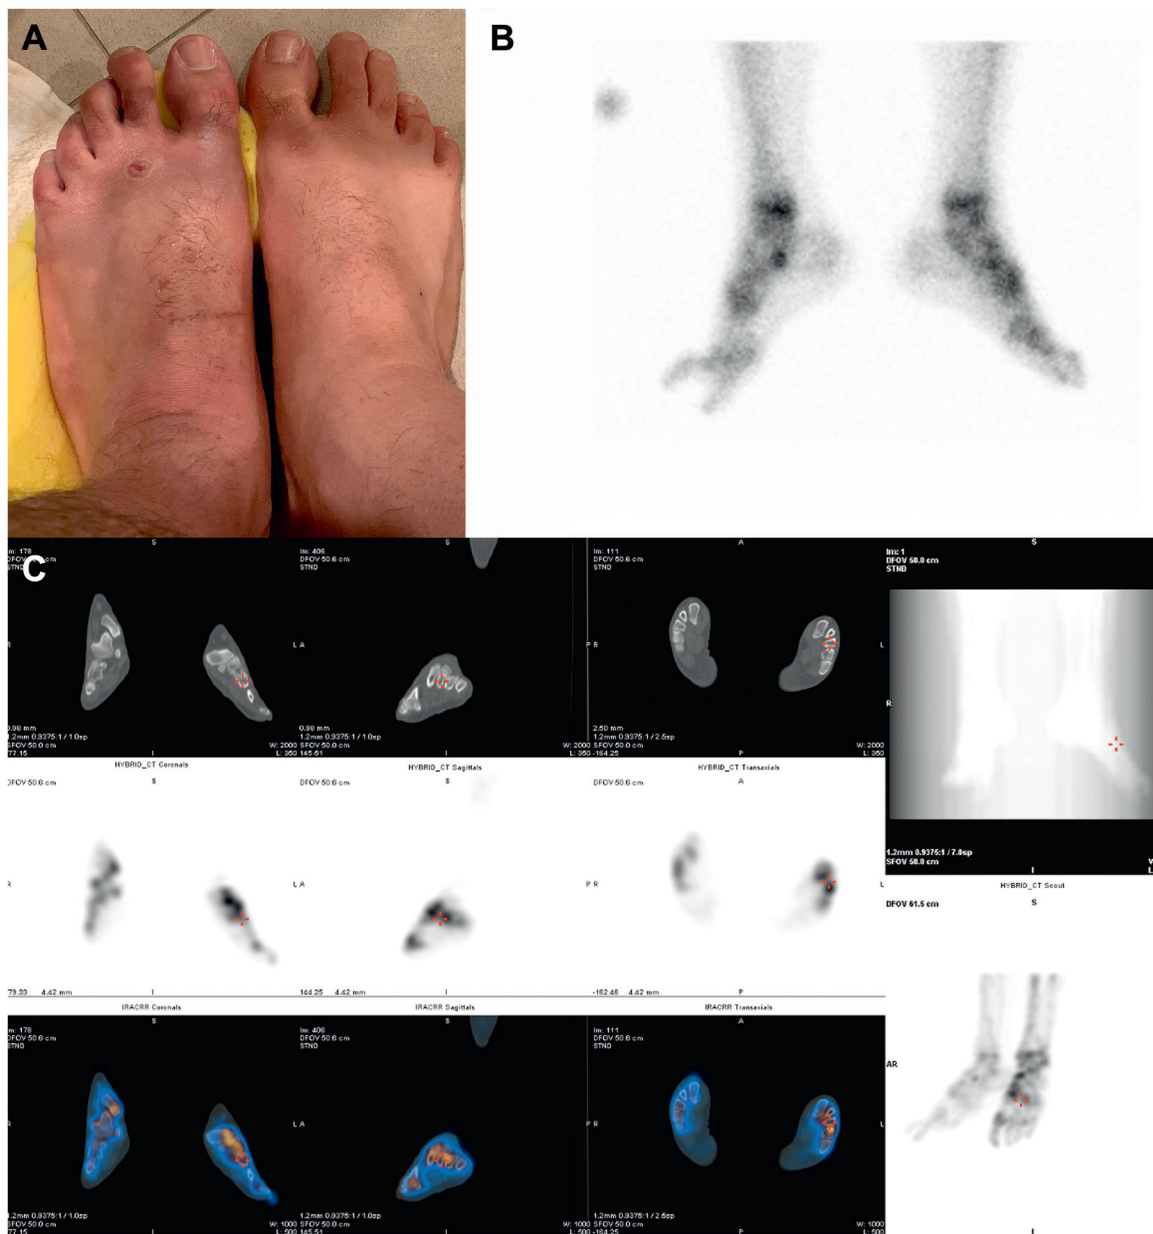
A: Complex regional syndrome. The left foot was presenting edema and burning pain, associated with hyperalgesia, allodynia, and abnormal temperature sensation; B and C: Delayed Images and SPECT CT images demonstrated increased periarticular tracer uptake in the left foot at the tibiotalar, fibulotalar, subtalar, talonavicular, naviculocuneiform, and the first and second tarsometatarsal joints.
